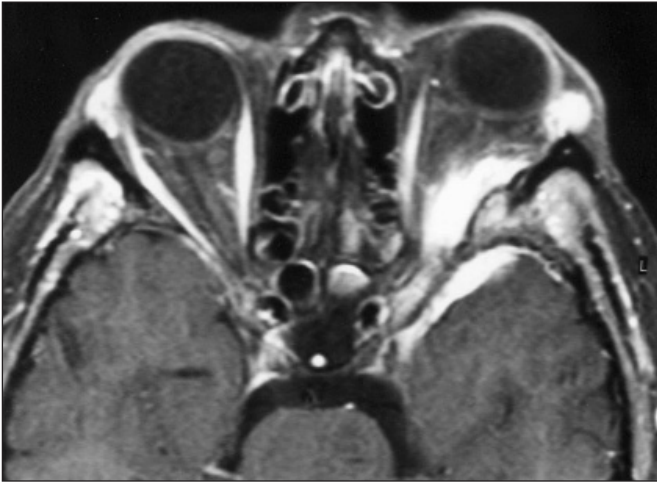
Preoperative magnetic resonance imaging of the orbit and brain with gadolinium, showing the en plaque meningioma extending to the orbit.
